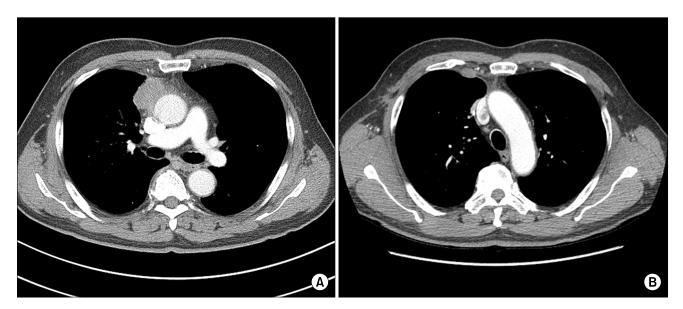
(A) Contrast-enhanced chest computed tomography scan, showing a 2.6-cm mass in the right anterior mediastinum. (B) Contrast-enhanced chest computed tomography scan, showing enlarged intrathoracic lymph nodes presumed to indicate recurrence.
